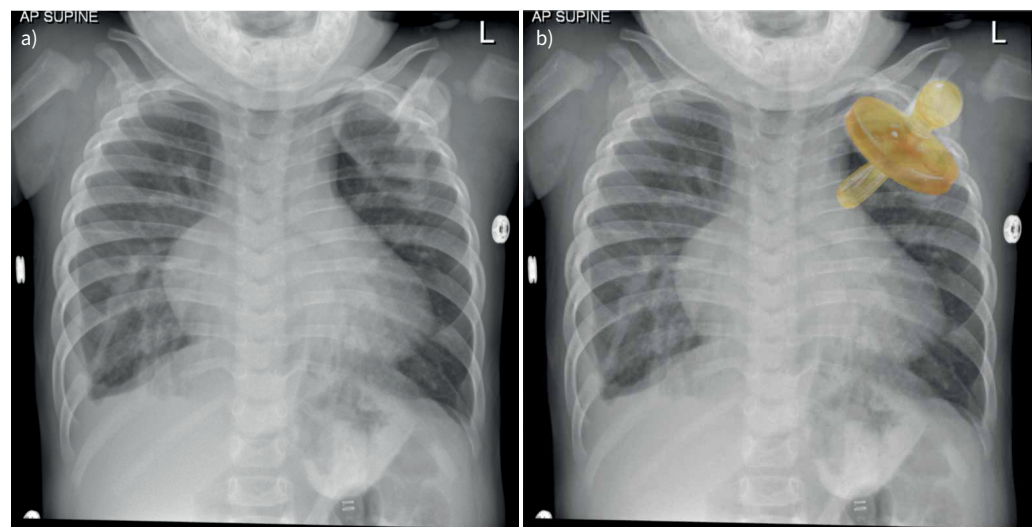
a) Chest radiograph; b) chest radiograph with dummy overlay.
